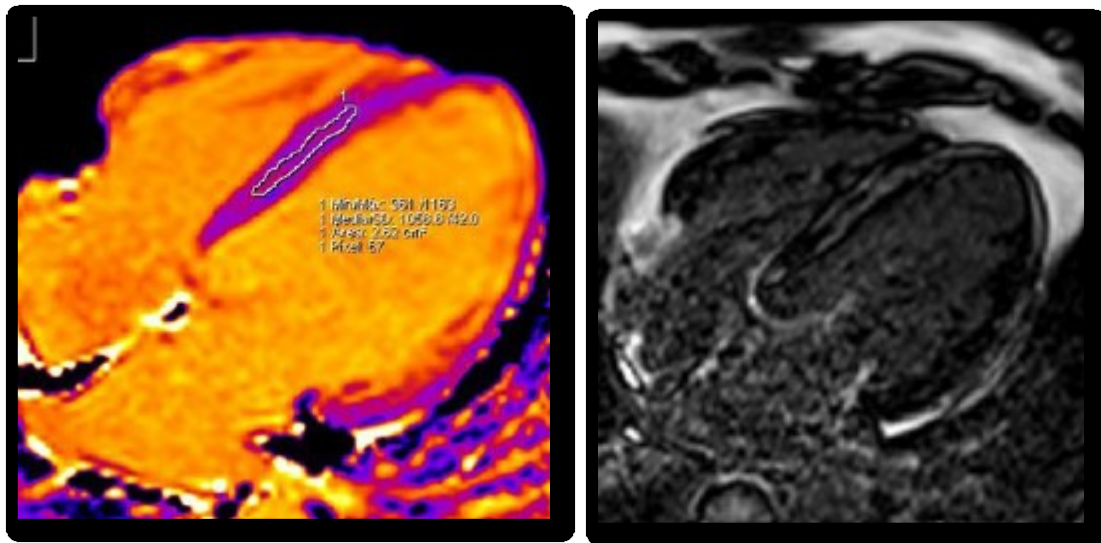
T1 mapping in nonischemic dilated cardiomyopathy. Four-chamber nonenhanced T1 map shows elevated diffuse T1 values (Left). Four-chamber LGE MR images show mesocardial enhancement.
